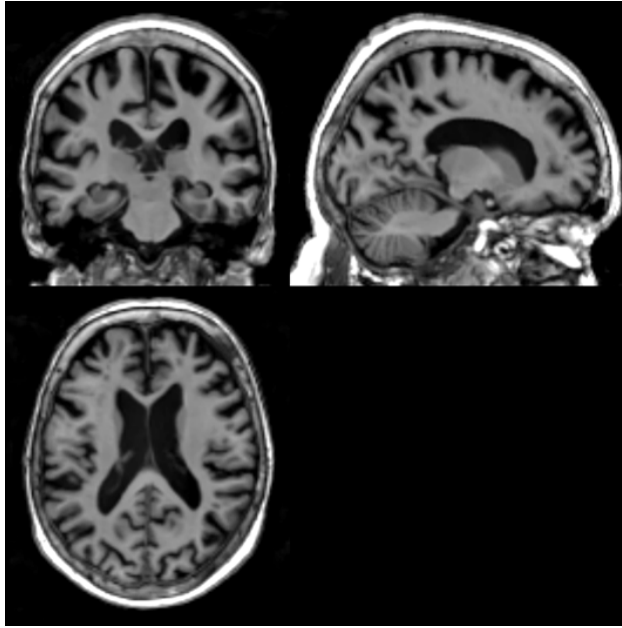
Structural MRI of the 136-S0299 AD subject from the ADNI dataset
